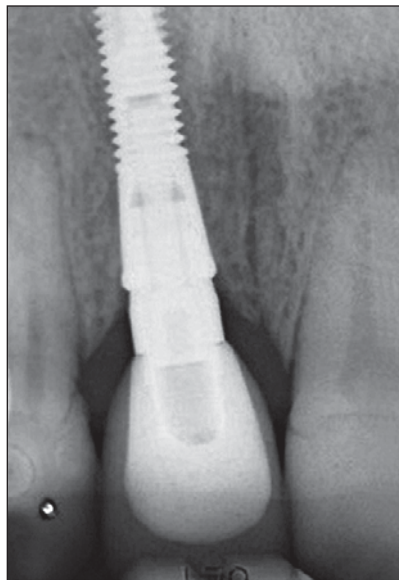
Radiographic evaluation of the implant-bone relationship 1 year following implant placement.
